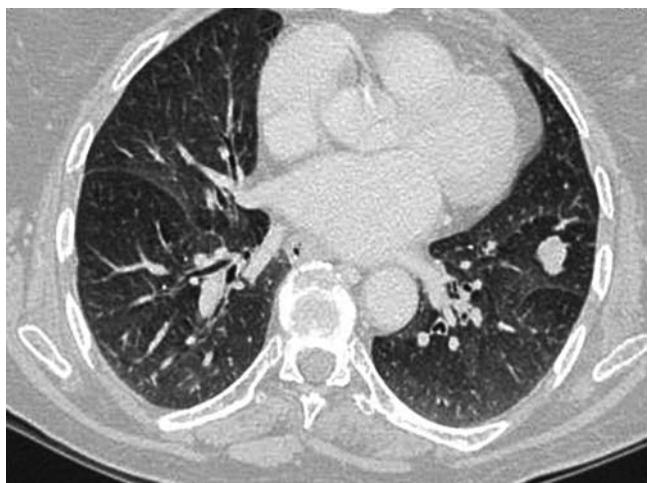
CT scan of chest, lung windows. Note peripherally located nodular lesion in the left lower lung zone. The lesion is away from the pleura.
